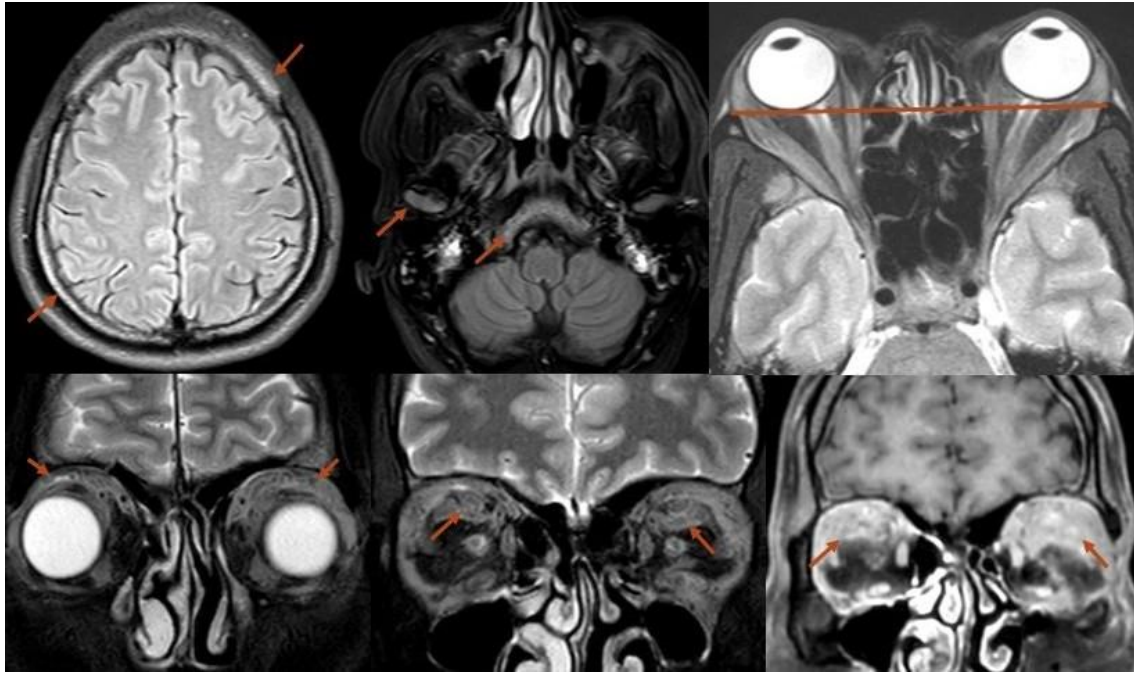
Diffuse FLAIR showing marrow hyperintensity involving the calvarium and figure 3 skull base and mandible. Figure 4. T2W1 showing bilateral proptosis with globes anterior to the interzygomatic line. Figure 5.T2W1 showing ill-defined soft tissue in the extraconal compartment of bilateral orbits predominantly along the roof, lateral wall and floor abutting the extraocular muscles.Figure 6. Ill-defined soft tissue is also noted in the intraconal compartment of bilateral orbits in the superior retrobulbar region on T2W1.Figure 7. TIC+ showing homogenous enhancement of soft tissue lesion.
